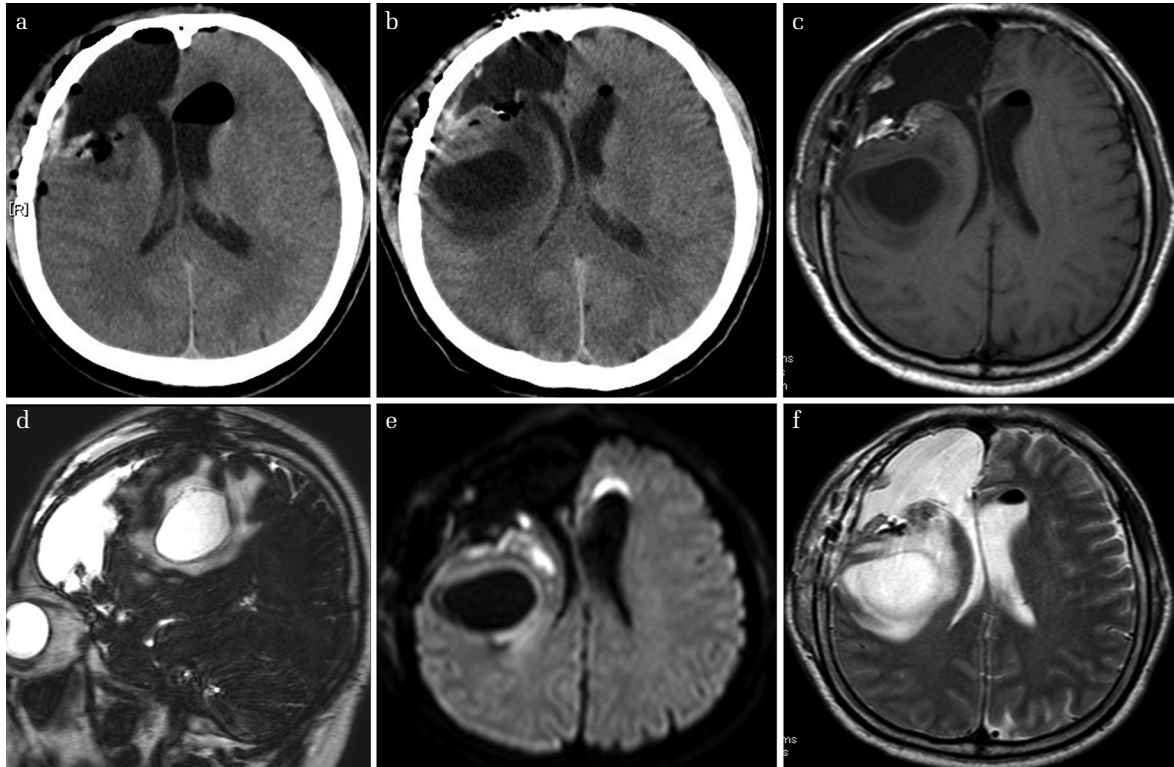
Consecutive postoperative neuroimaging. Computed tomography (CT) scan on 4th day after the surgery shows no cyst formation (a). CT and MRI on the 7th day after the surgery reveals remote cyst formation (b–f). The cyst is apart from the resection cavity on sagittal T₂-weighted MRI (d). No abscess evidence on diffusion-weighted images (e). Signal intensity of liquid content of the cyst is almost the same as the cerebrospinal fluid (CSF) on T₂-weighted MRI (f).
